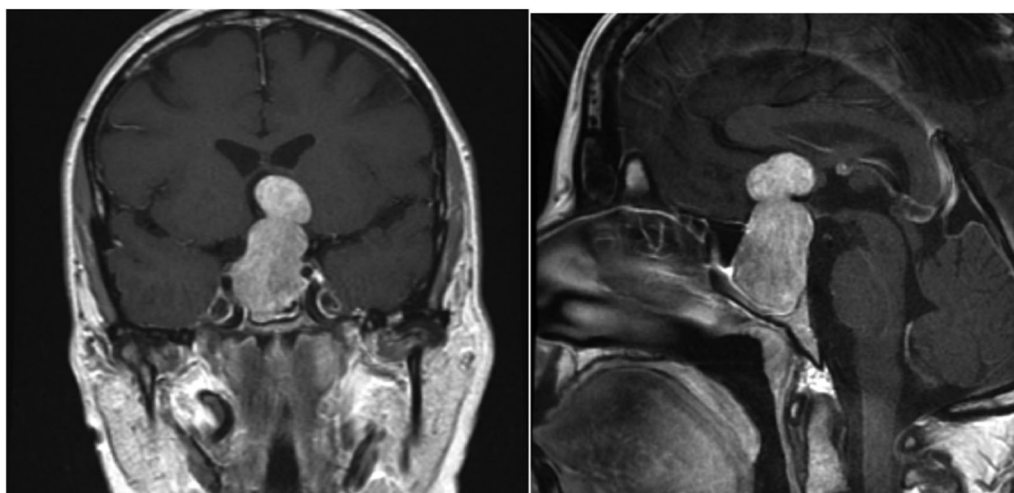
Magnetic resonance imaging pituitary coronal and sagittal planes: a 48 mm × 27 mm × 21 mm lobulated, well-circumscribed, heterogeneously enhancing extra-axial mass centred on the pituitary fossa with significant extension into the suprasellar cistern and interhemispheric fissure closely applied to the adjacent Circle of Willis vessels and bowing the chiasm significantly.
